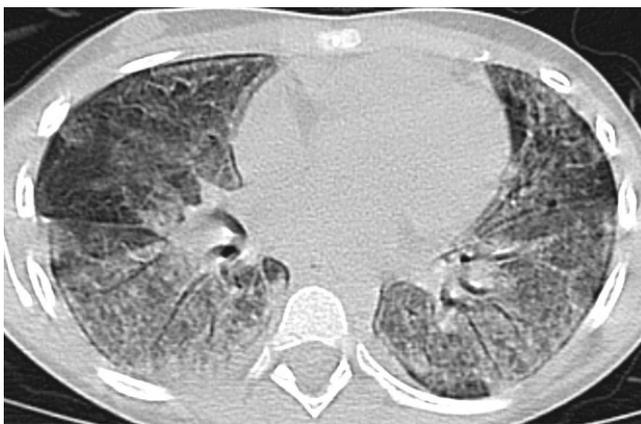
An 8-year-old girl with a confirmed diagnosis of H1N1 and respiratory failure requiring non-invasive ventilation. Computed tomography scans acquired 4 days after the onset of clinical symptoms show severe and diffuse ground-glass opacities without specific distribution in the lungs.
